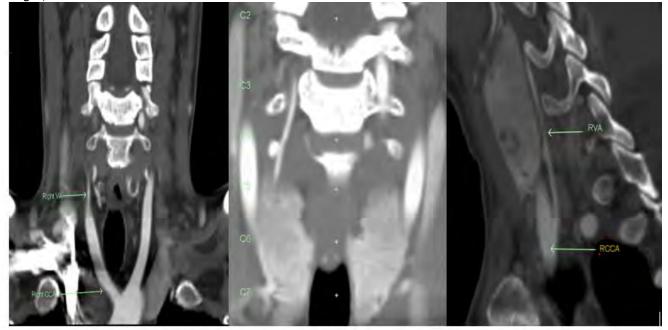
Coronal and sagittal CTA neck images show a hypoplastic right vertebral artery (VA) arising from the right common carotid artery (RCCA) with a retro thyroid course.
